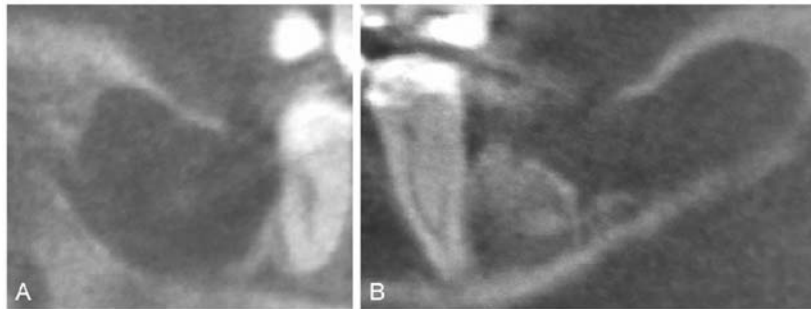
Representative sagittal tomograms from cone beam tomography of the (A) right and the (B) left side. The radiotranslucency is sharply demarcated. A: Only the caudal border of the mandibular canal is depicted in continuity. B: The tomogram from a far lingual aspect (tooth 38 is not depicted), showing that the cyst is incompletely covered by bone.
